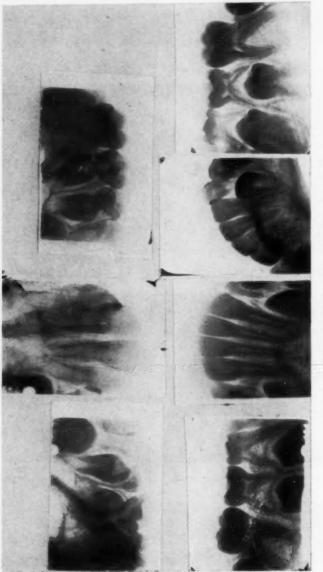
Radiographs of teeth prior to treatmen
